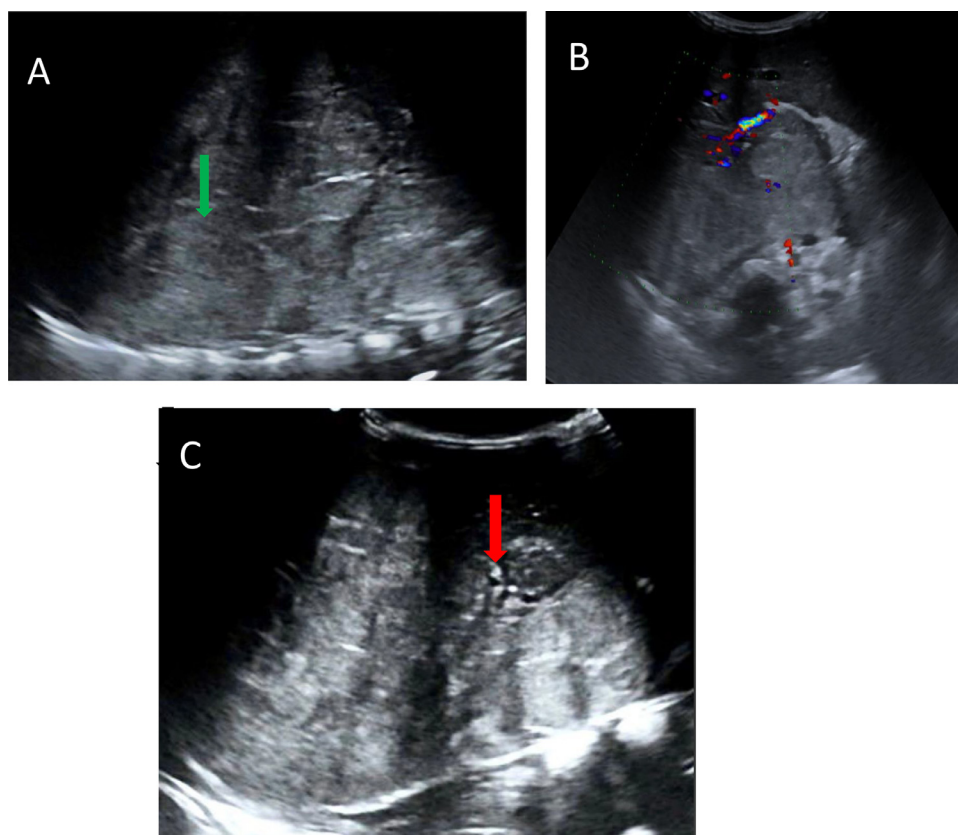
Abdominal ultrasound revealing a large right hepatic mass with a smooth slope connecting to the hepatic parenchyma, grossly rounded, poorly defined, exhibiting heterogeneous isoechoic echotexture (A: red arrow) containing areas of fluid and calcifications (C : red arrow), and taking moderately the color Doppler (B).
